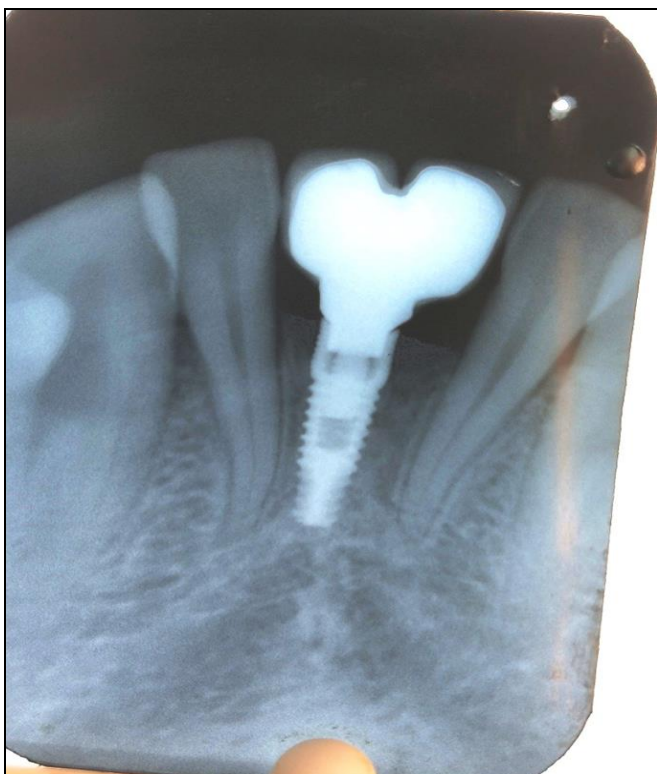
Radiograph of implant with prosthesis
